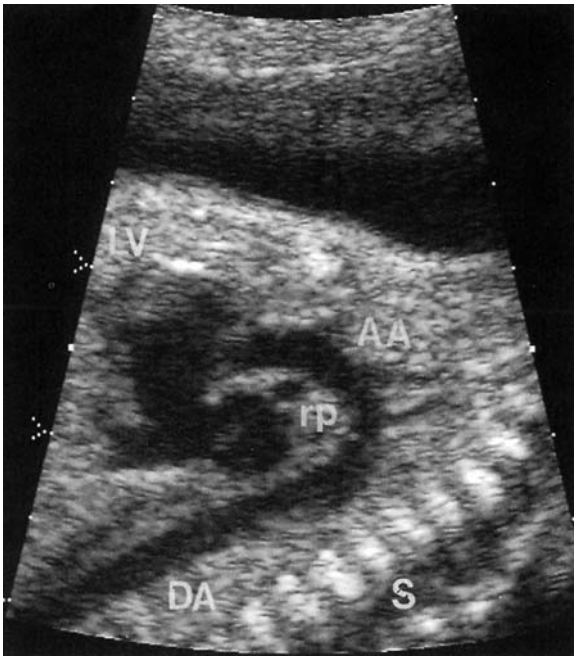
Method for obtaining the aortic arch view of the fetal heart. *Far left:* Orientation of the transducer plane in relation to the fetal thorax. *Middle:* Echocardiographic plane in relation to the fetal heart
